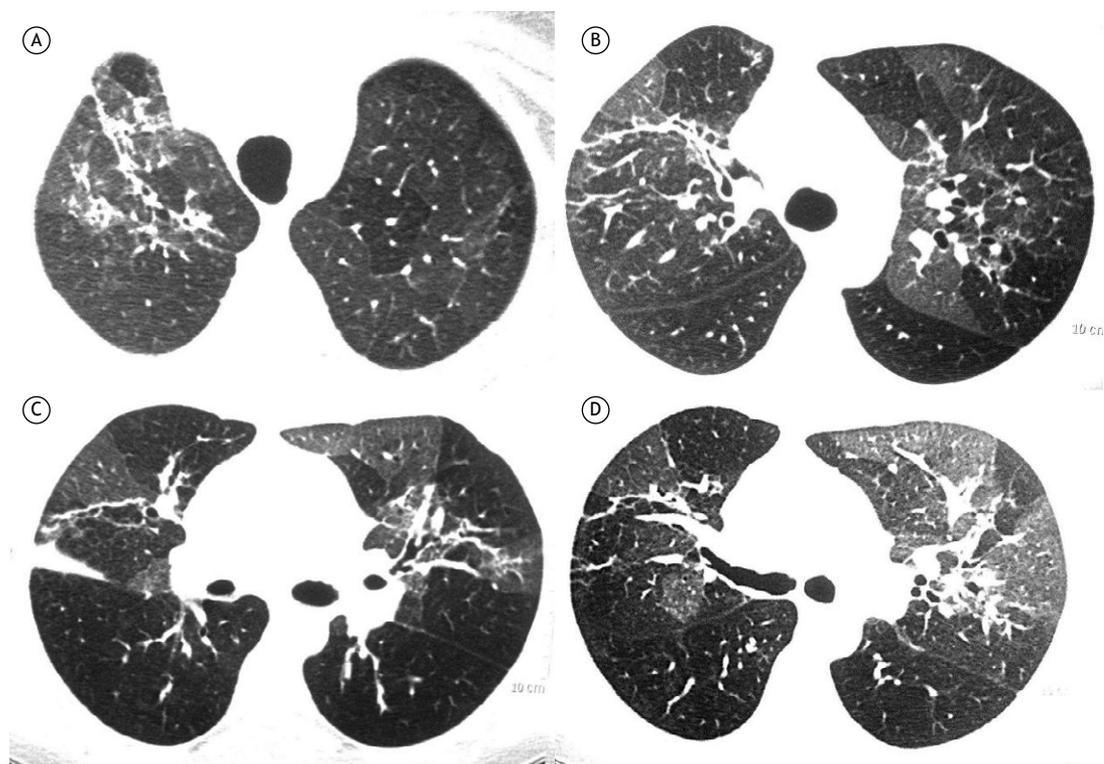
HRCT performed two months after hospital admission, showing pulmonary parenchyma with a pattern of attenuation in diffuse mosaic, with extensive areas of regional hyperinflation and discrete reticular infiltrates associated with ground-glass areas dispersed bilaterally in the anterior segments, notably in the left lung.
